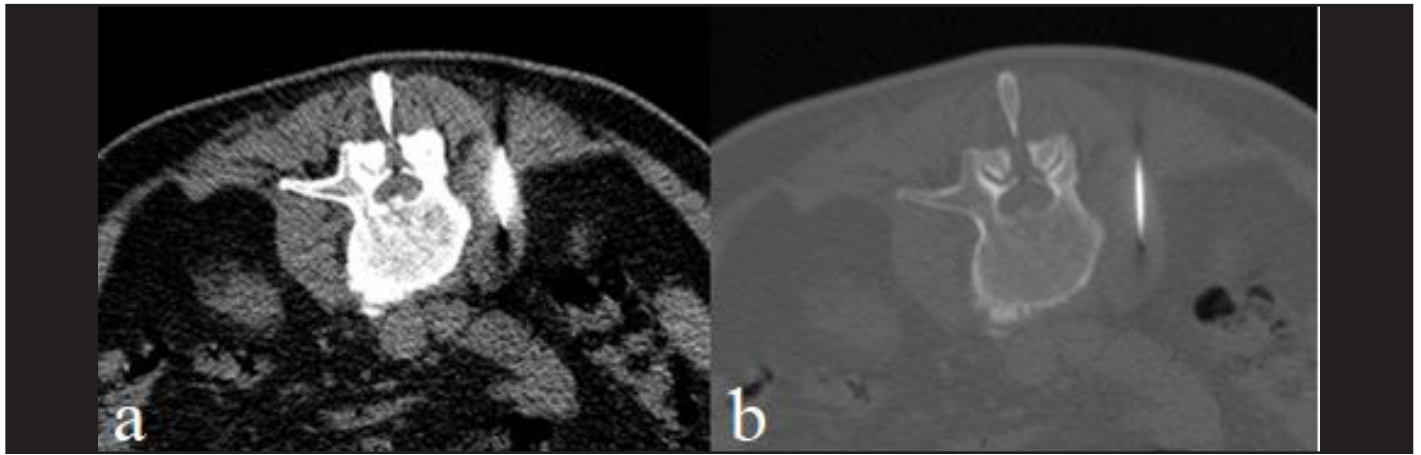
A: The sample (same patient as Figure 1) is depicted in the soft tissue window. B: The sample shows the bone window. An axial unenhanced CT image, taken with the patient in the prone position during percutaneous biopsy, reveals the needle (white arrow) in the paravertebral soft tissues adjacent to the L3 vertebral body. The pathology report noted the presence of acute and chronic osteomyelitis. Cultures from the biopsy showed the presence of *Staphylococcus aureus* infection.
